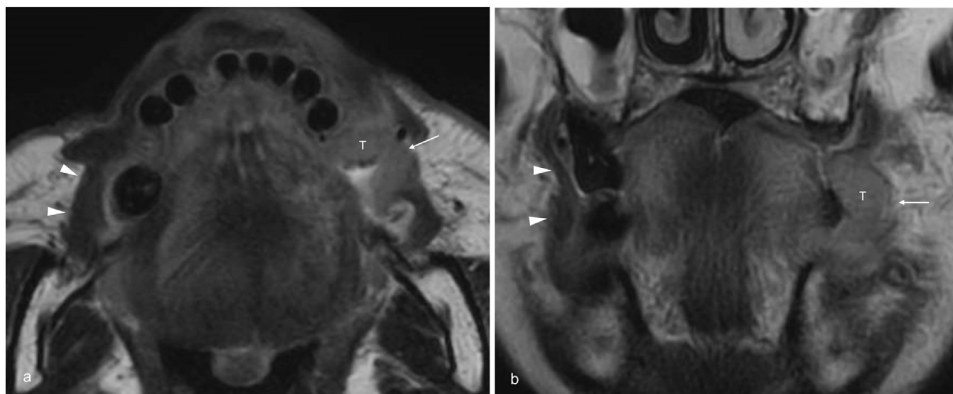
Magnetic resonance imaging findings of buccal fat pad invasion. A 66-year-old male with squamous cell carcinoma of the left buccal mucosa. (a) Axial and (b) coronal T2-weighted images reveal squamous cell carcinoma of the buccal mucosa (T) with invasion through the buccinator muscle into the left buccal fat pad (arrow). The right buccinator muscle (arrowheads) is normal.
